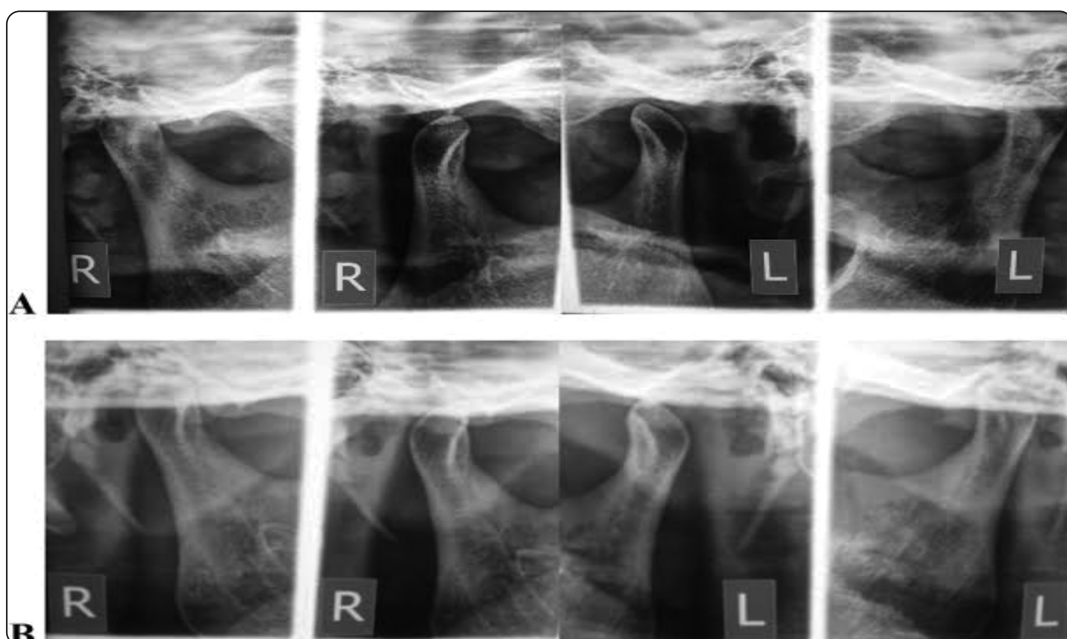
A radiograph shows the difference in condyle location before and after treatment
